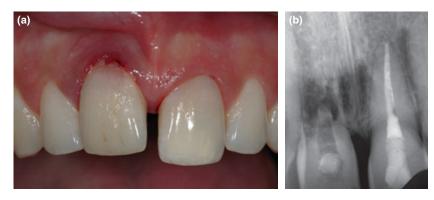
(a, b) Complete root resorption of the central incisor (11): clinical and radiographic views.
